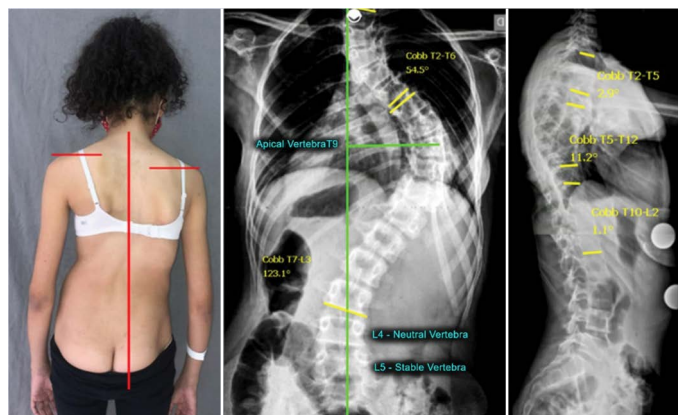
Example of preoperative clinical and radiographic evaluation of curves using the Cobb method.
